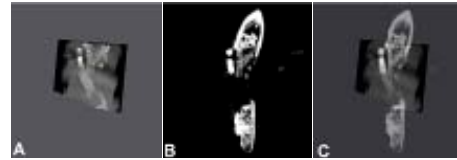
Microradiograph (A), CT image (B) and Fusion of both (C).
